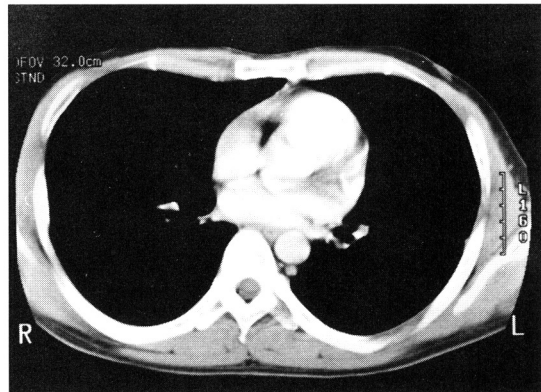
CT scan of the chest 2 months after a combination treatment with corticosteroid and chlorambucil showing complete resolution of preexisting aneurysms.
